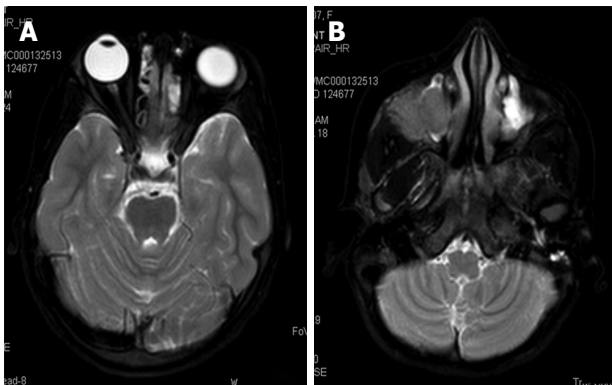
The whole body magnetic resonance imaging showing presence of bilateral ethmoid and maxillary sinusitis along with replacement of normal marrow by focal lesions involving maxilla. A: Axial TSE T2-weighted fat suppressed image of normal orbits; B: T2WFS axial image of the face showing isointense soft tissue filling the right maxillary sinus with extension into the infratemporal fossa. TSE: Turbo spin-echo; T2WFS: T2-weighted fat-suppressed.
